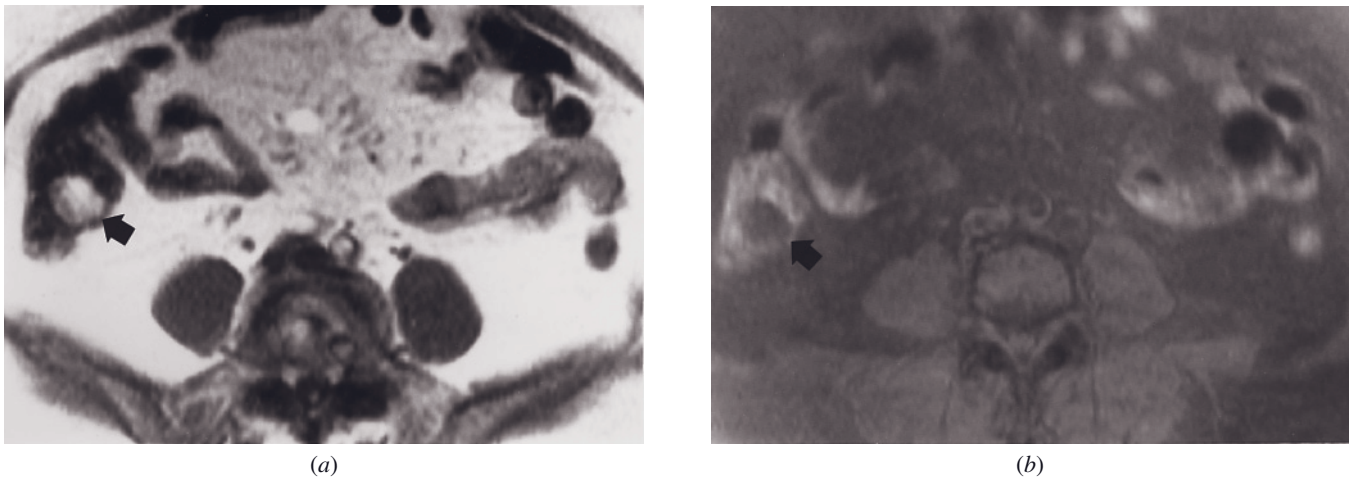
Cecal lipoma. SGE (*a*) and T1-weighted fat-suppressed spin-echo (*b*) images. A mass in the cecum is high in signal intensity on the T1-weighted image (arrow, *a*) and diminishes in signal intensity on the fat-suppressed image (arrow, *b*). These imaging characteristics are pathognomonic for a fat-containing tumor. The cecum is a common location for large bowel lipomas. (Reprinted with permission from Shoenut JP, Semelka RC, Silverman R, Yaffe CS, Mickflikier AB: Magnetic resonance imaging evaluation of the local extent of colorectal mass lesions. *J Clin Gastroenterol* 17: 248-253, 1993.)
